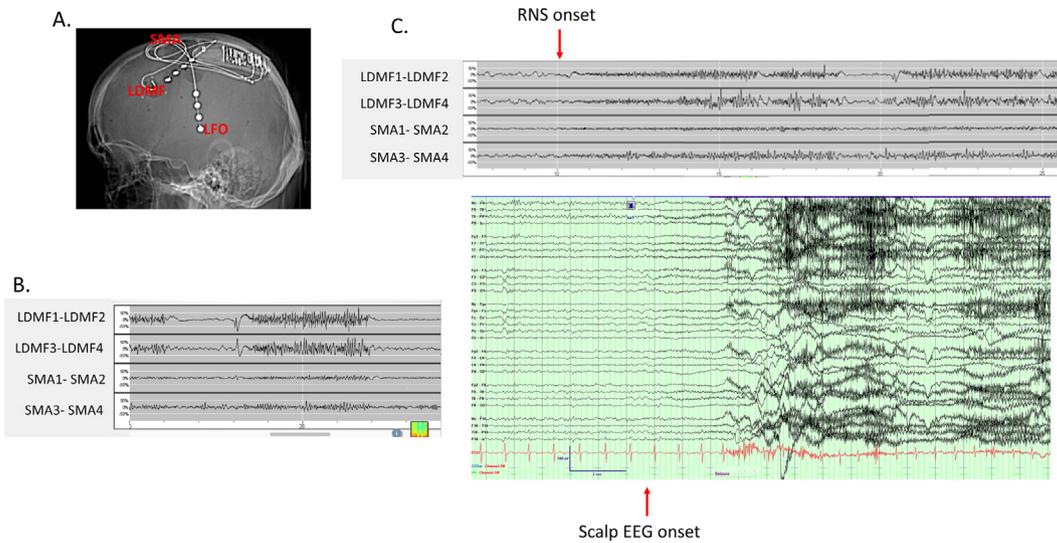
RNS data. A. CT showing the configuration of the previously placed RNS leads. Initially the left frontal depth (LDMF) and the lateral frontal cortical strip (LFO) were placed. However, due to lack of efficacy, LFO was disconnected and a strip over the supplementary motor area (SMA) was placed. There was an attempt at lead removal, but due to adhesions, this was not possible. B. RNS EEG data showing presumed seizure activity (or robust interictal activity) in the LDMF leads, consisting of a spike-wave complex followed by a high frequency discharge. C. Simultaneously acquired RNS ECoG (top) and scalp EEG (longitudinal bipolar montage) from EMU admission (bottom). Seizure onset in RNS occurs in LDMF electrode and precedes scalp onset by around 1 s. Ictal activity resembles that observed at other times in the RNS data (as in panel B).
